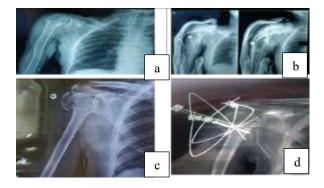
(a-d): Preoperative radiographs on the lefthand side and postoperative radiographs on the righthand side, with mini open CC screw technique done is shown in right lower radiograph.
